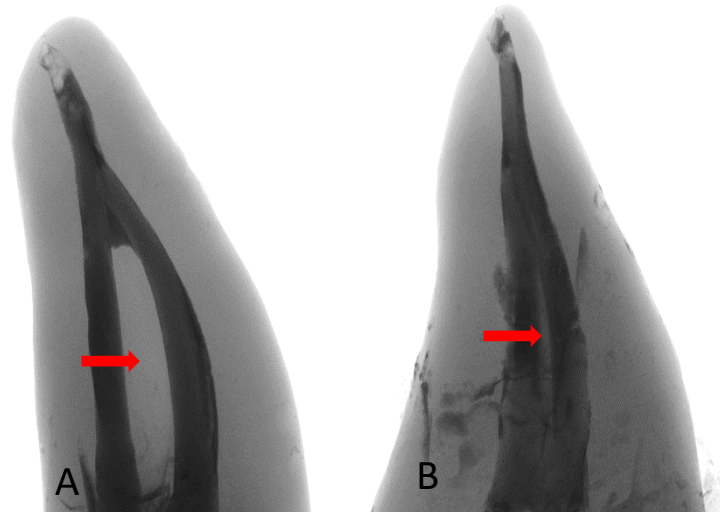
Inverted colour of the reconstructed images showing the typical μ CT appearance of obturated molars A: single-cone technique and B: WVC technique. Root canals are filled with root canal filling.
